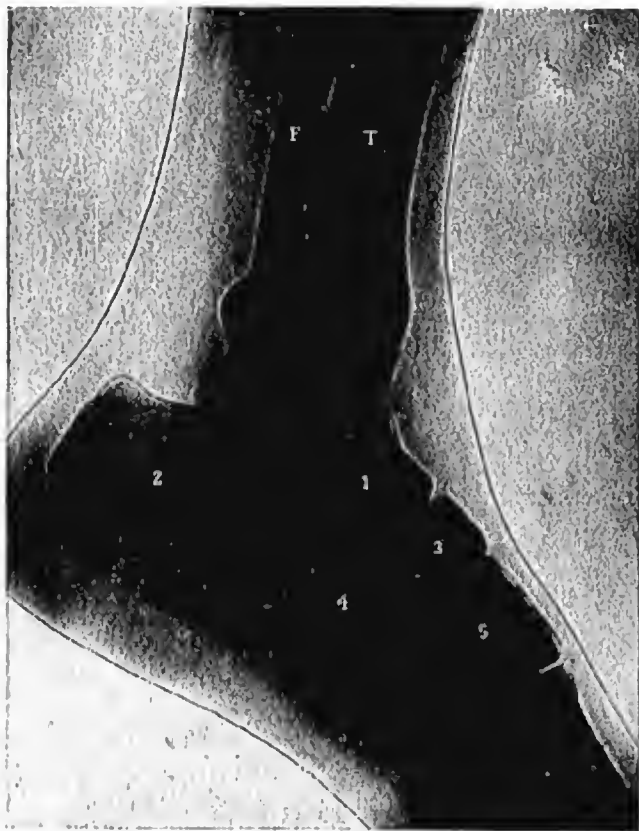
X-ray of normal foot. F, Fibula. T, Tibia. 1, Astragalus. 2, Os Calcis. 3, Scaphoid. 4, Cuboid. 5, Cuneiform.
